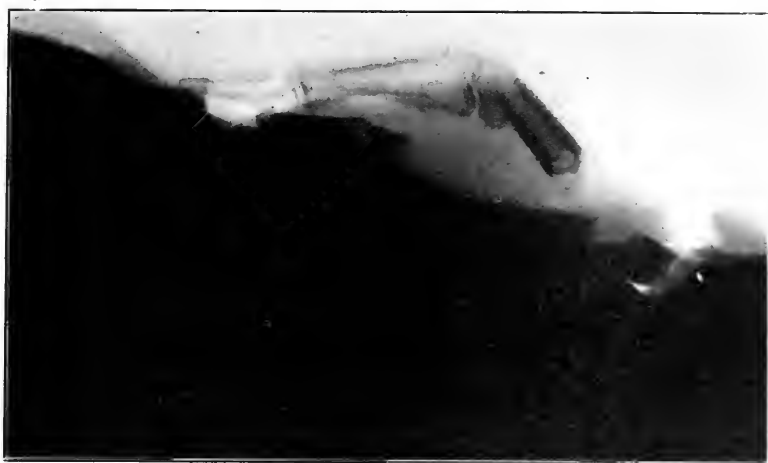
Roentgenogram of result after proximal phalanx had been turned antero-posteriorly. Distal phalanx in contact with frontal bone.
